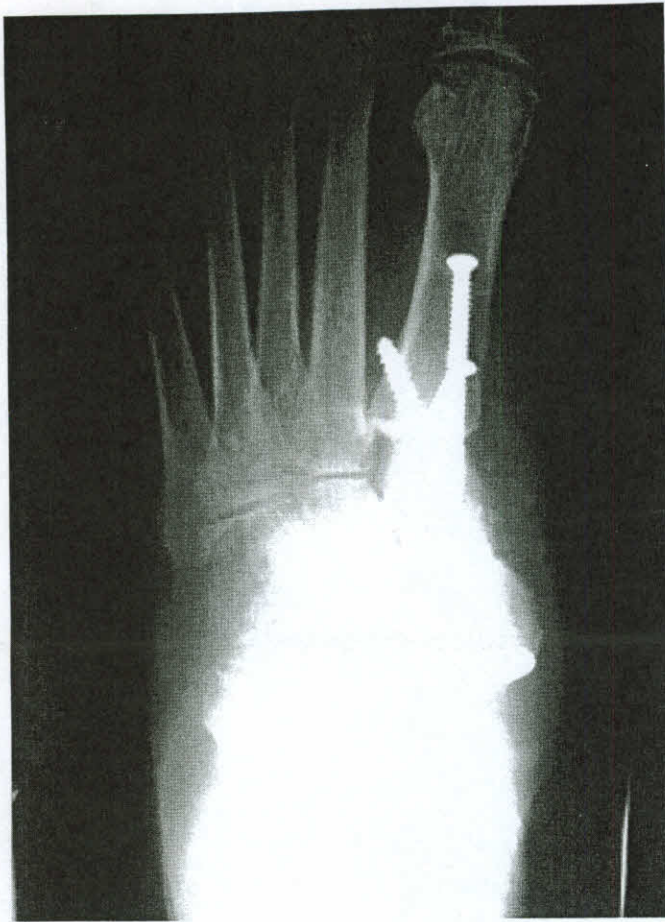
Postoperative anteroposterior radiographic view of the left foot in weight bearing.
